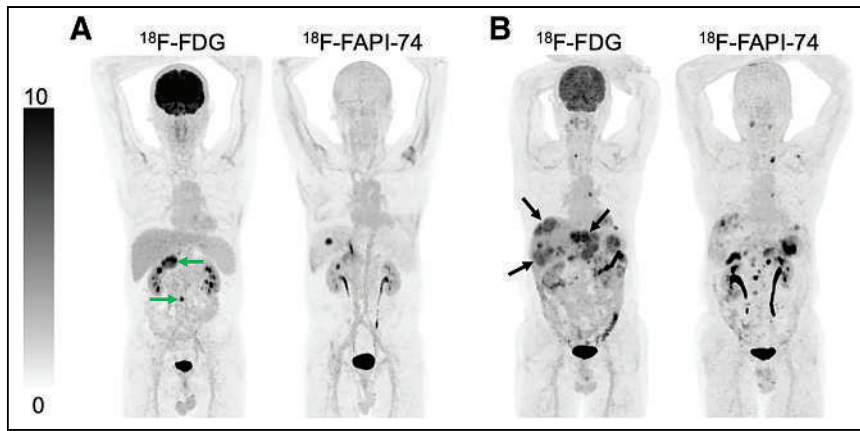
(A) 46-y-old man underwent ^{18}F -FDG PET/CT for recurrence detection with subsequent biopsy-confirmed abdominal LN metastases. It shows high radiotracer uptake in abdominal LN metastases (arrows). ^{18}F -FAPI-74 PET/CT shows lower radiotracer uptake and fewer abdominal LN metastases. Focal activity in liver indicates physiologic uptake in gallbladder. (B) 62-y-old man with pathologically confirmed liver cancer underwent initial staging with ^{18}F -FDG PET/CT, which shows more intrahepatic metastases with higher tracer uptake (arrows) than did ^{18}F -FAPI-74 PET/CT.
